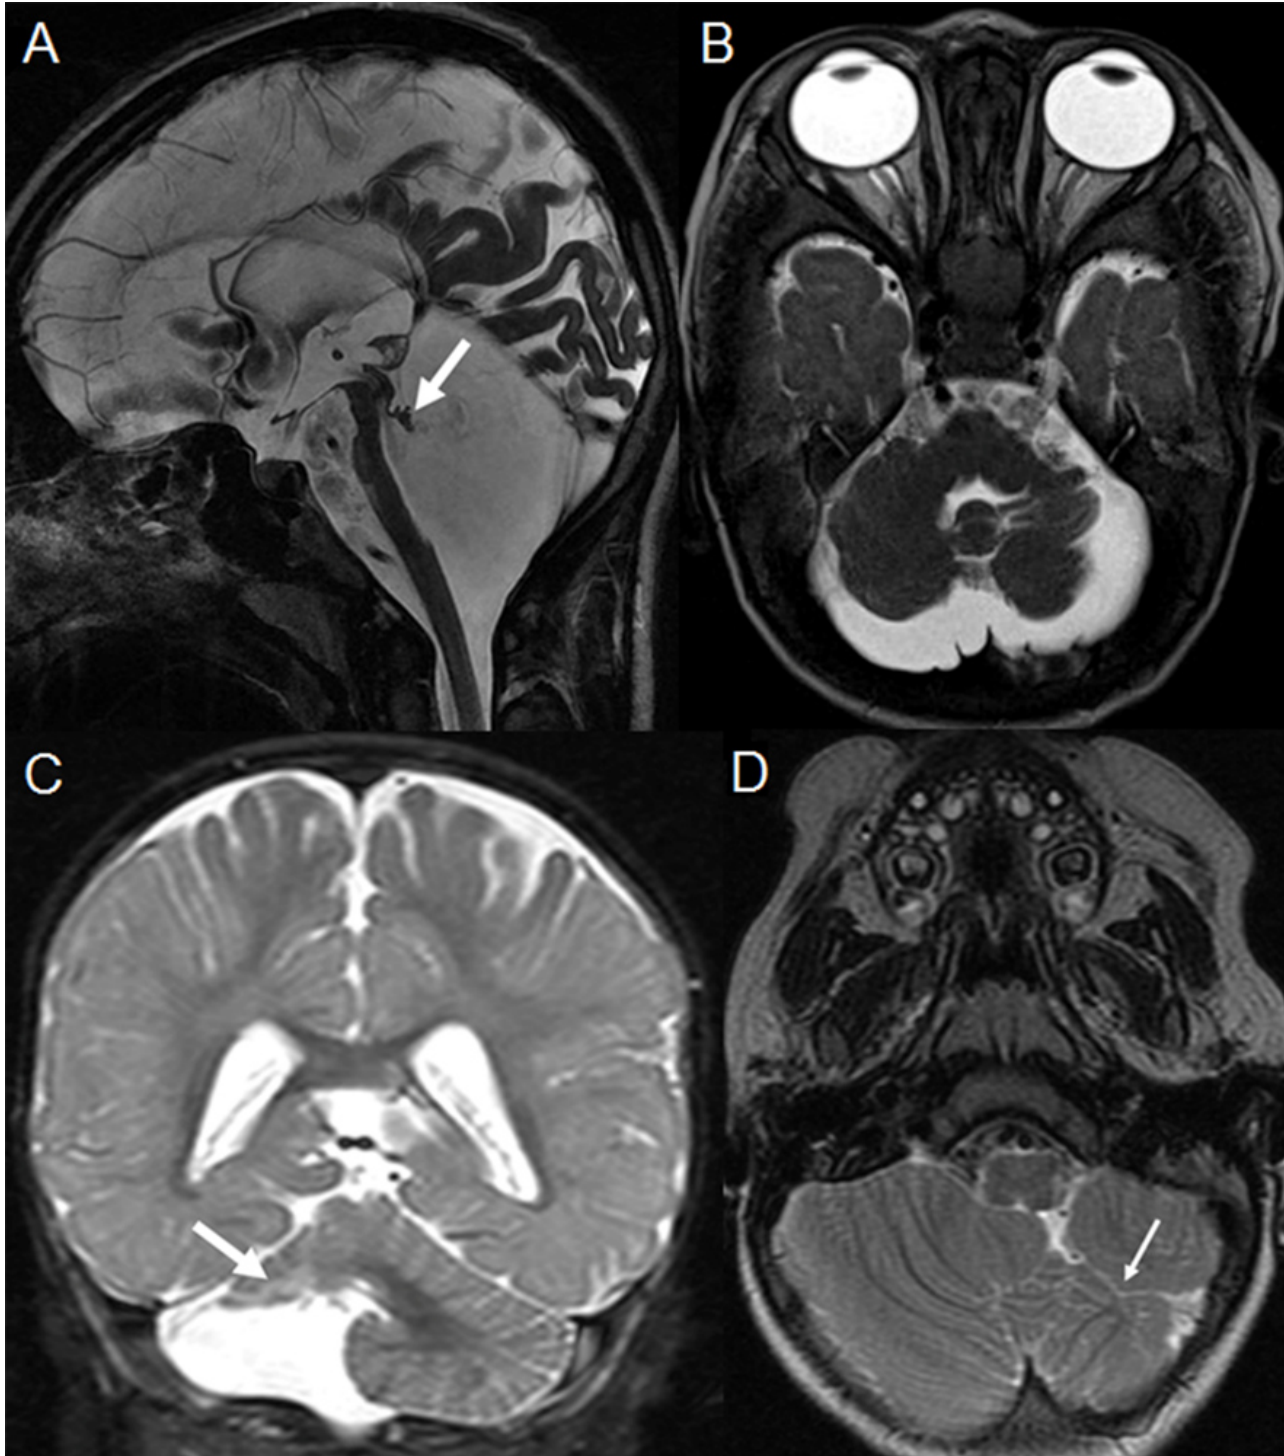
A. Sagittal magnetic resonance (MR) image of a child with cerebellar agenesis shows near-complete absence of the cerebellum except for a rudimentary remnant (arrow); B, Axial MR image of a child with global hypoplasia due to prenatal cytomegalovirus infection shows global reduction in size of the cerebellum; C, Coronal MR image of a child with unilateral cerebellar hypoplasia shows almost complete absence of the right cerebellar hemisphere (arrow); D, Axial MR image of a
